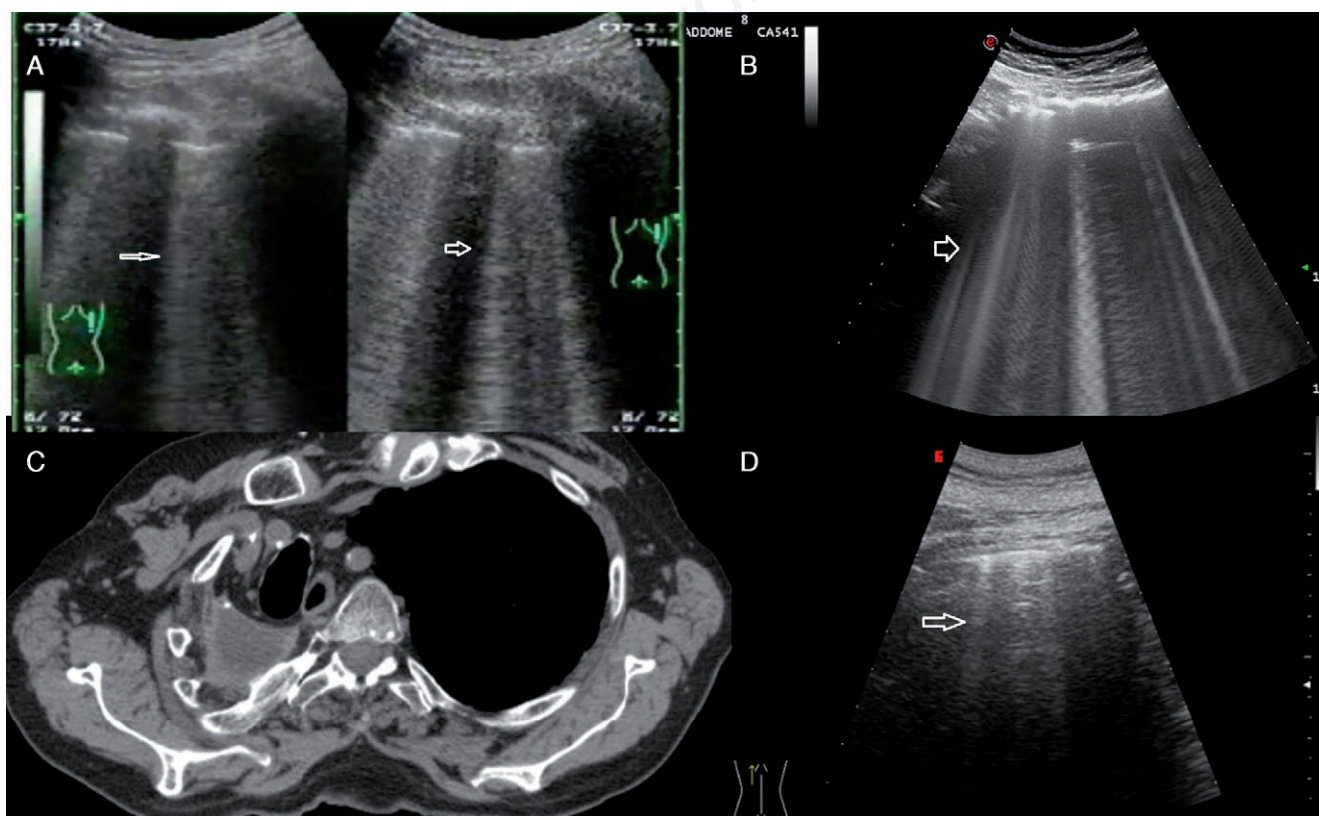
The *B line* in different contexts. A) Transthoracic ultrasound (TUS) showed hyperechoic pleural line and *B line* below it (white arrows). B) Abdominal scan showed hyperechoic peritoneal line and *B line* below it (white arrows). C, D) Computed tomography corresponding and TUS in residual cavity post pneumectomy a showed hyperechoic line and *B line* (white arrows).
